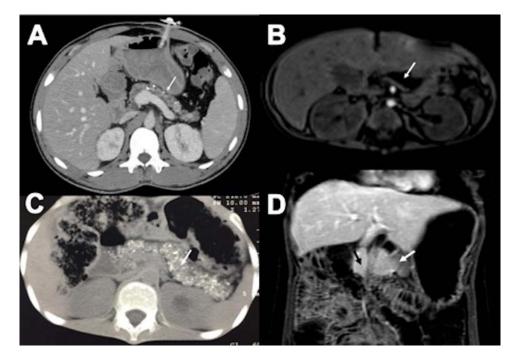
Figure I (A) Computed tomography (axial view) of a 8-year-old patient with cystic fibrosis showing pancreatic atrophy and pancreatic calcifications (white arrow). (B) Magnetic resonance cholangiopancreatography (axial view) of an infant with exocrine pancreatic insufficiency from Pearson syndrome showing pancreatic atrophy with fatty replacement (white arrow). (C) Computed tomography (axial view) of a 5-year-old patient with exocrine pancreatic insufficiency from tropical calcific pancreatitis showing extensive pancreatic calcifications (white arrow). (D) Magnetic resonance enterography (coronal view) of a 4-year-old patient with exocrine pancreatic insufficiency showing annular pancreas (white arrow) and pancreatic hypoplasia with small body and tail of the pancreas (black arrow).
